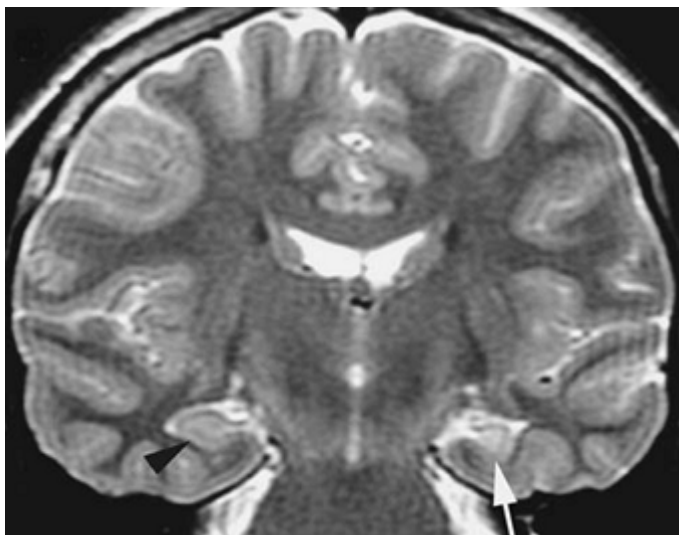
This 24-year-old woman had left temporal lobe epilepsy. The coronal T2-weighted images show increased signal and reduced volume (*white arrow*). The contralateral hippocampus is normal
